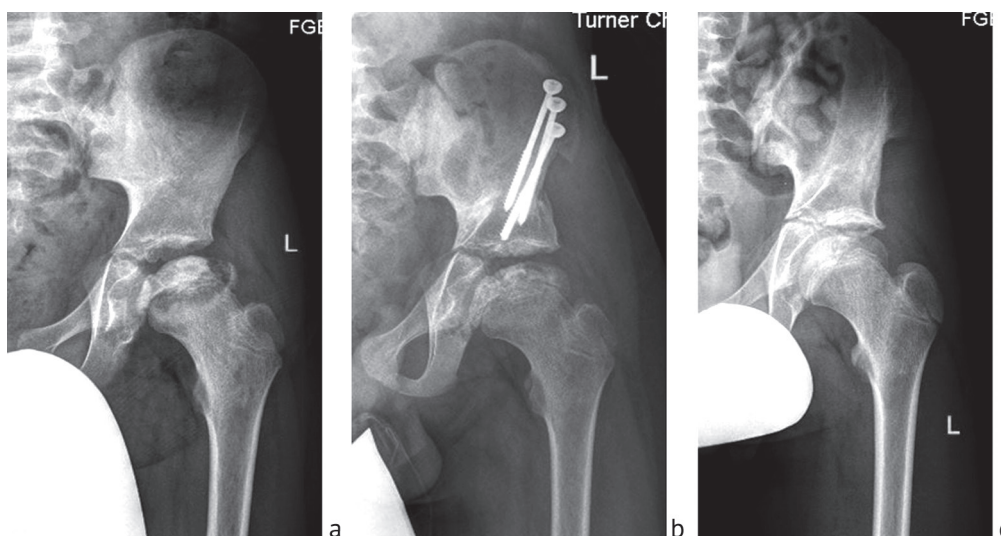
X-rays of the hip joints in patient A., 8 years old, left-side LCPD: *a* before surgery; *b* three months after triple pelvic osteotomy on the left side; *c* 3-year outcome after triple pelvic osteotomy on the left side
